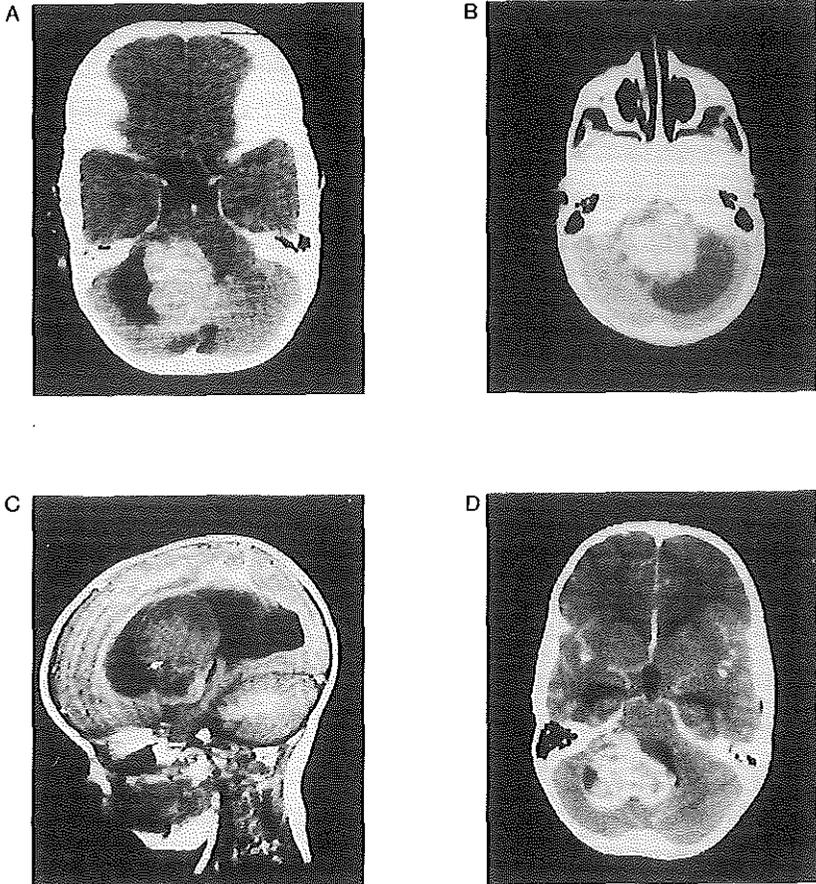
Cerebral scans. A, CT of patient A, showing a infratentorial tumor with contrast enhancement. B, CT of patient B. C, MRI of patient C, showing a large supratentorial intraventricular tumor. D, CT of patient D.
